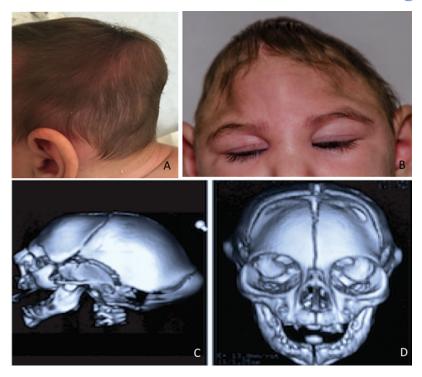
The occipital prominence can be pronounced and evident on external inspection (A) and represents the parietal-occipital junction with a very hypoplastic occipital bone on reconstructed CT image (C). A frontal midline bulge is apparent due to significant depression of the lateral aspects on the frontal bone (B), which appear more depressed than the parietal bones along with obvious supratemporal depression on CT (C and D). The vertical dimension of the cranium is reduced and the parietal vault is narrow (B and D). [Color figure can be viewed at wileyonlinelibrary.com]
